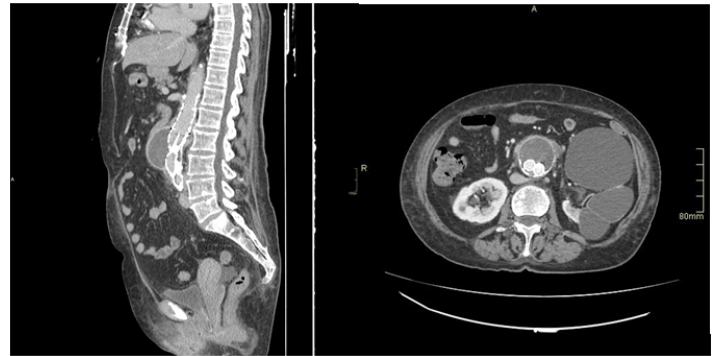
Contrast-enhanced CT images reveal aorto-bi-iliac stent graft with abnormal thickness of the left aortic aneurism wall and adipose tissue inhomogeneity.
